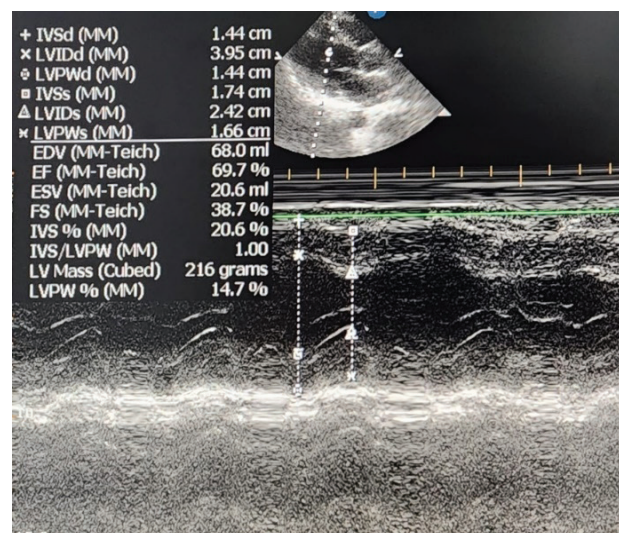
Echocardiography result
